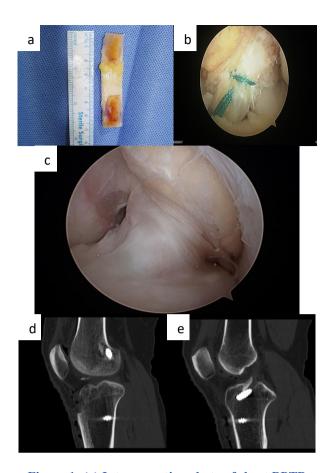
(a) Intraoperative photo of short BPTB graft 65 mm. (b) Arthroscopic image showing reconstructed ACL using BPTB graft. (c) Second look arthroscopic image after 19 months post op. (d) Sagittal CT SCAN showing proximal graft migration. (e) Sagittal CT SCAN showing intraarticular bone plug migration.
